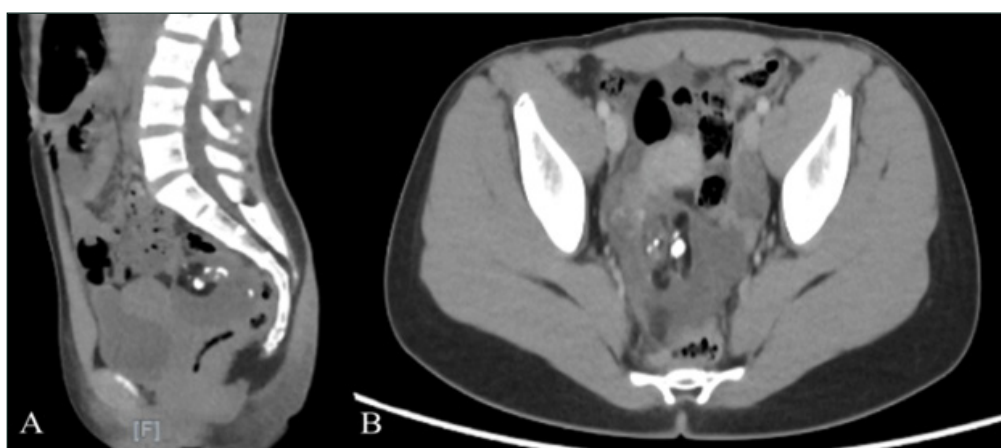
Pelvic CT Showing Cystic Ovarian Lesion
